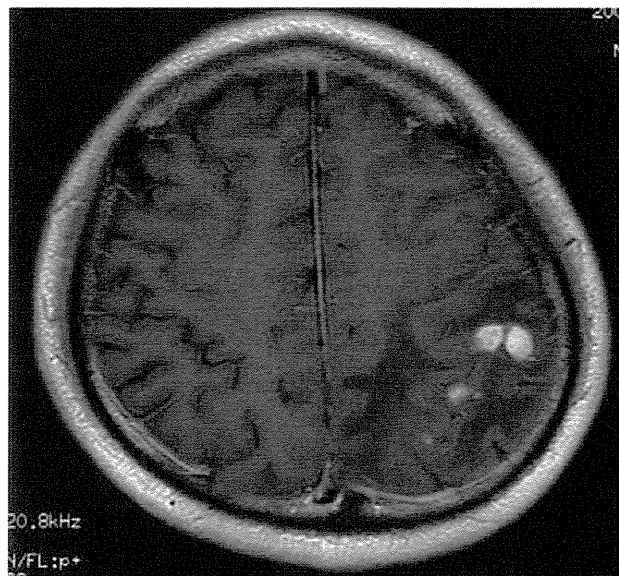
T1-weighted MRI scan with enhancement, obtained at admission, showed tumor-like lesions in the left parietal lobe with the presence of edema.
